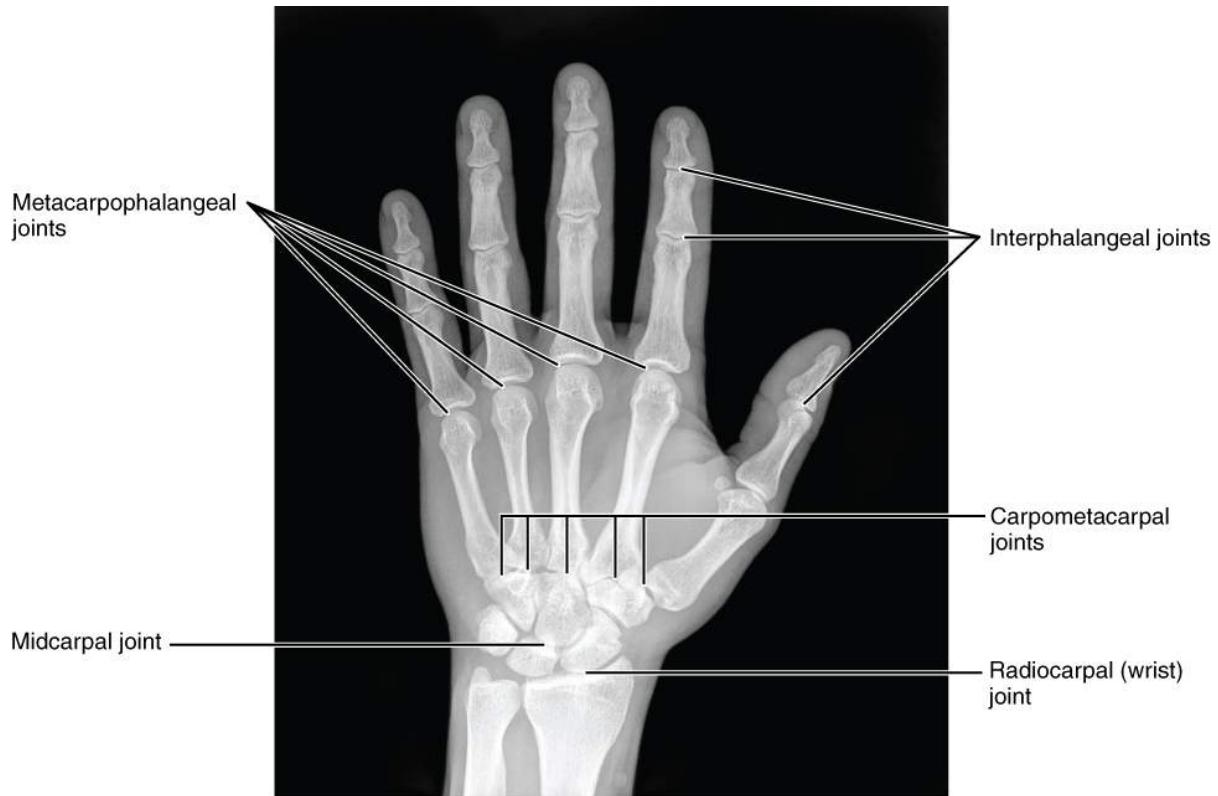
Bones of the Hand: This radiograph shows the position of the bones within the hand. Note the carpal bones that form the base of the hand. (credit: modification of work by Trace Meek)
